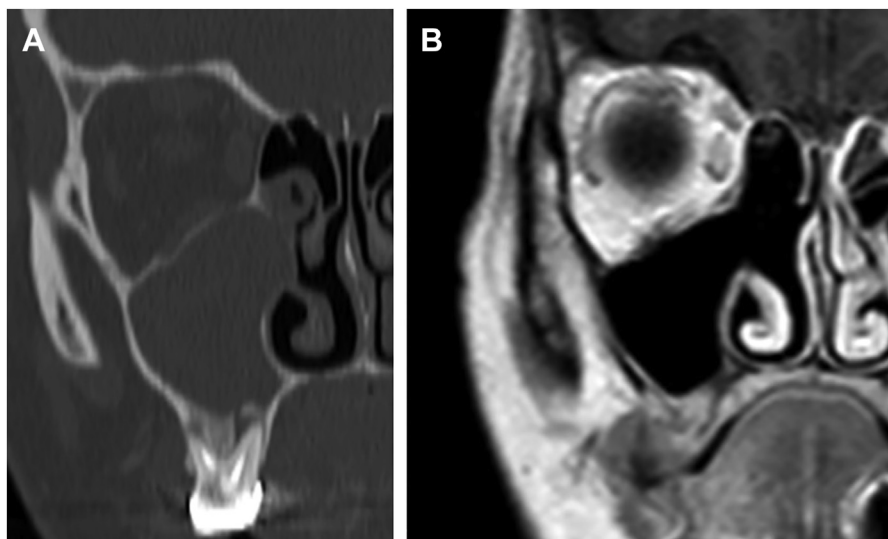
Example of persistent right-sided ODS affecting maxillary and ethmoid sinuses following an RCT that failed to resolve both the apical periodontitis of a maxillary molar and the ODS. (A) Coronal CT showing complete maxillary sinus opacification after prior RCT, and the molar still demonstrated a periapical radiolucency with bone erosion (though no dental symptoms). The patient was miserable from sinusitis symptoms, so underwent ESS next, followed by molar extraction because the RCT was deemed not revisable. (B) MRI (obtained for non-sinusitis reasons) showing a widely patent maxillary antrostomy and anterior ethmoidectomy, and absent molar.
